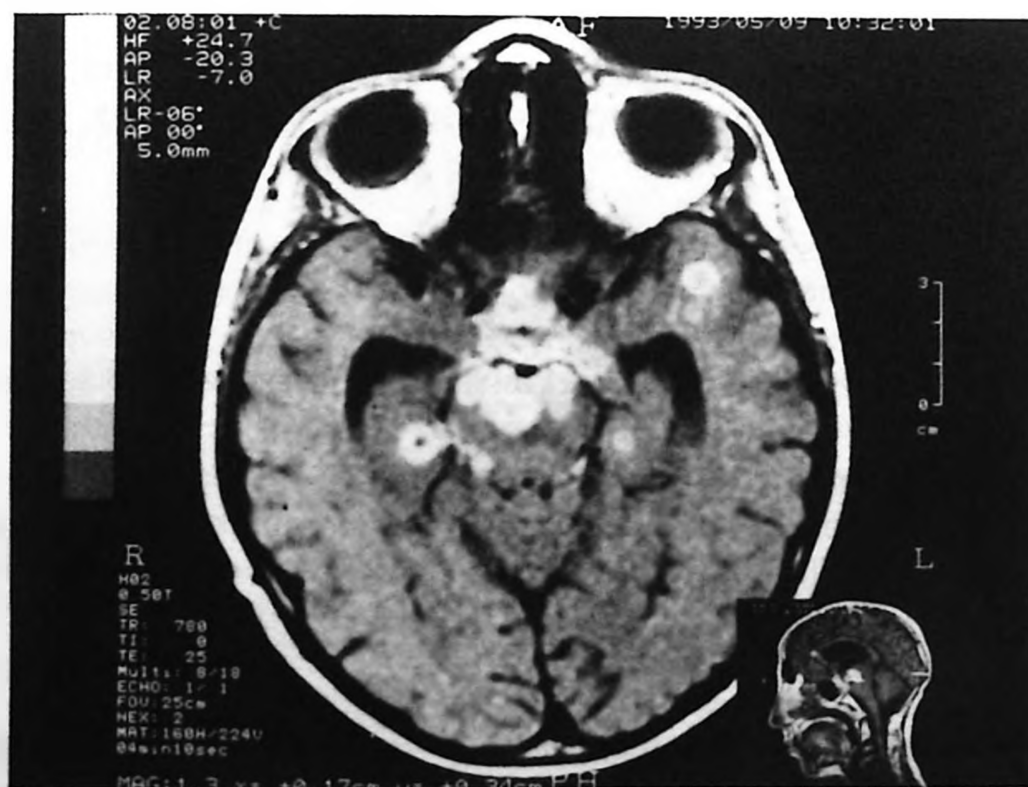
Axial T1-weighted MR image after gadolinium injection showed multiple tuberculomas enhancing in the mesencephalon, suprasellar cistern and bilateral hippocampi, and a nodular enhancing lesion in the corpus callosum was noted on the sagittal "survey" view.
